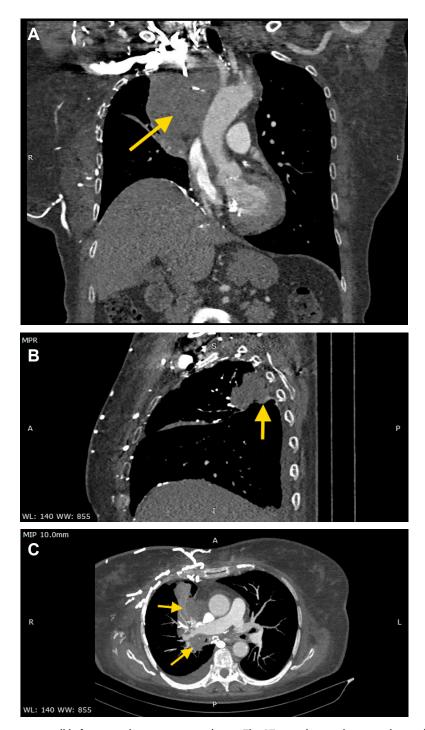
Lung cancer responsible for a superior vena cava syndrome. The CT scan detects the tumoral mass (arrow): A – coronal reconstruction; B – sagittal reconstruction; C – axial reconstruction in maximum intensity projection [MIP]
